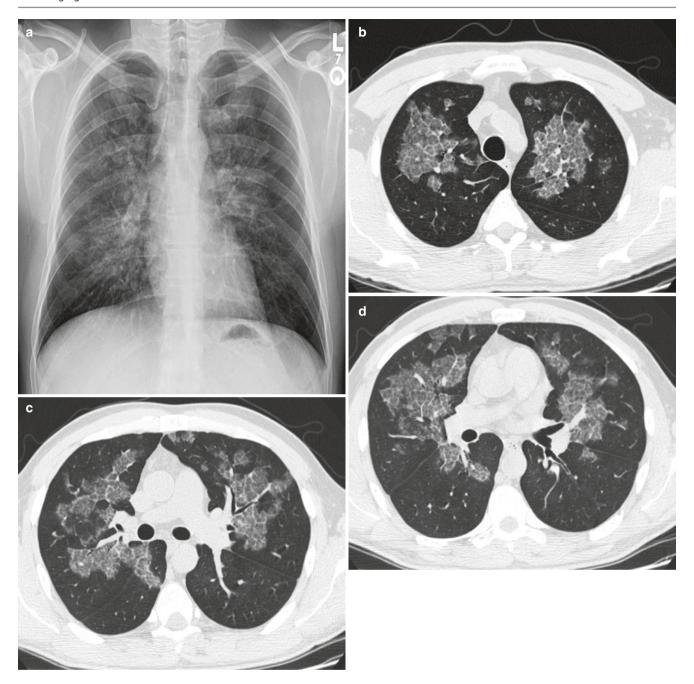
Primary alveolar proteinosis in a 40-year-old man from GM-CSF antibodies. (a) Frontal chest radiograph shows parahilar ground-glass opacities without cardiomegaly. (b-d) Axial CT images show "sharply marginated" areas of "crazy-paving" pattern
